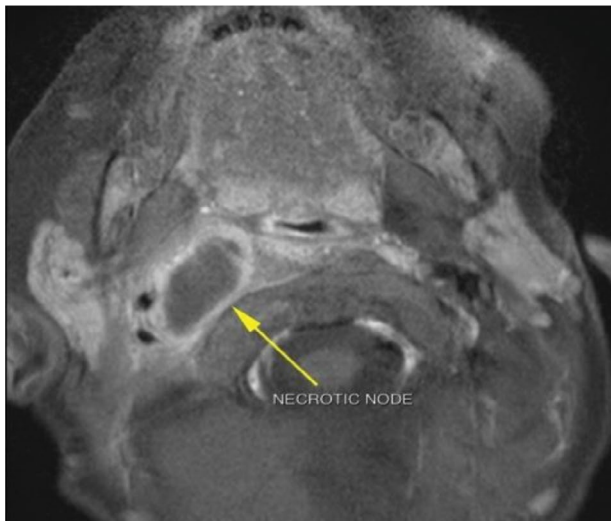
Preoperative axial T1 weighted MRI showing necrotic node in the retropharyngeal space displacing the carotid sheath
